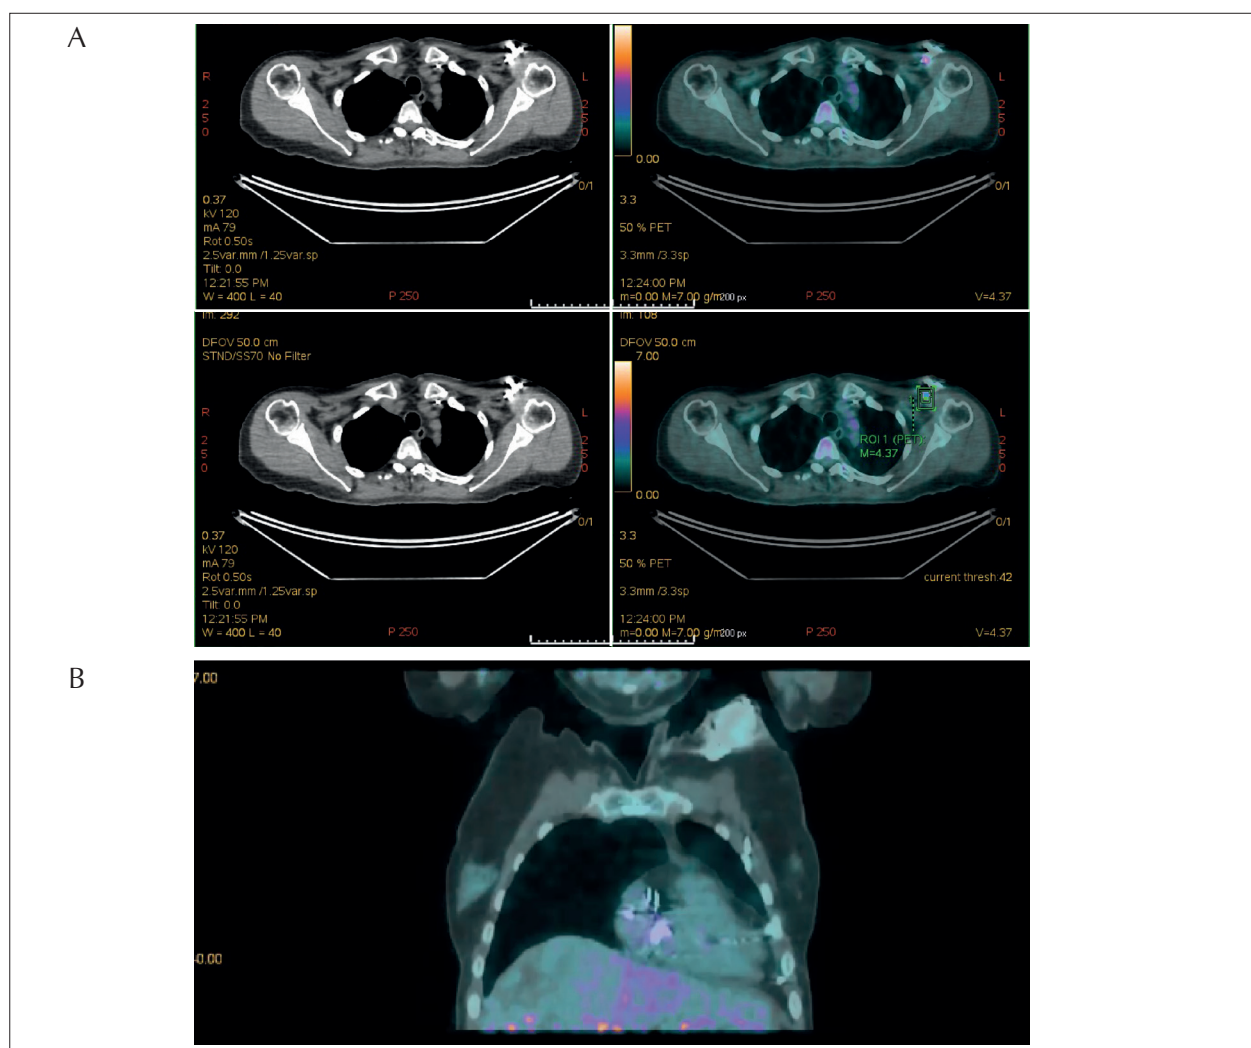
Male patient, 55 years old, diabetic, with tricuspid bioprosthesis and pacemaker with epicardial and transvenous leads. The patient showed clinical signs of pacemaker pocket infection. PET/CT with 18-FDG was performed to rule out pacemaker lead infection. Increased uptake of F18-FDG was observed in the pacemaker pocket, confirming the diagnosis of local infection (A). Pacemaker leads did not present any uptake, hence ruling out lead infection diagnosis (B).
